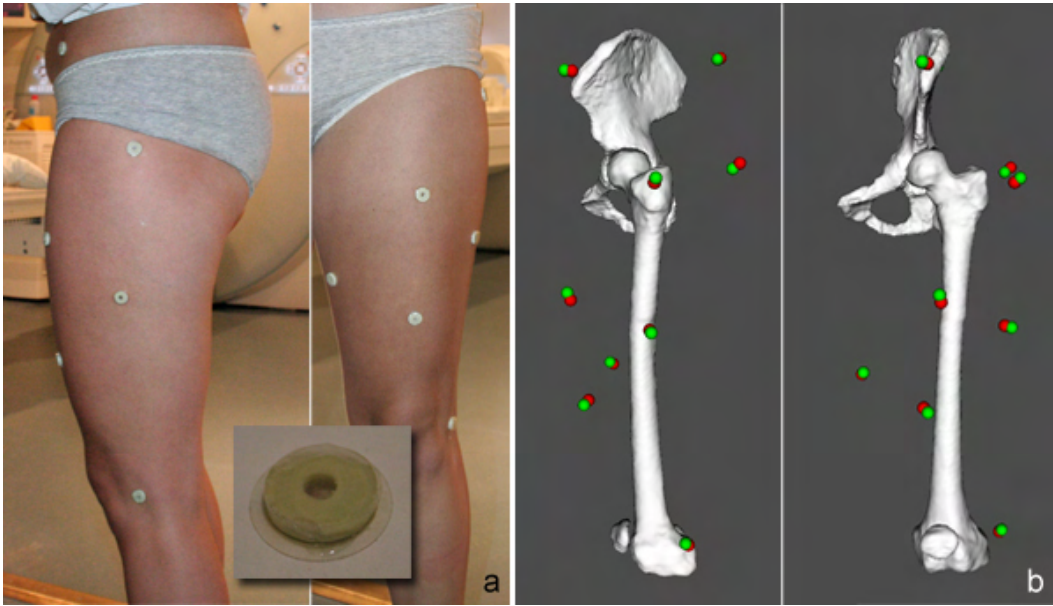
a) MRI-compatible markers setup b) Error made on the skin markers after anatomical calibration: green = real markers positions (MRI-compatible markers), red = registered skin markers.
